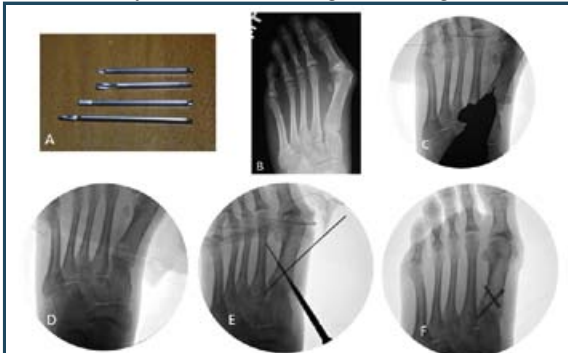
A: Isham burrs. B: X-ray showing hallux valgus deformity. C, D: Percutaneous lateral closing wedge osteotomy using an Isham burr under fluoroscopy to correct the varus deformity of the first metatarsal. E and F: insertion of two cannulated screws over the guide wires with the metatarsal in normal alignment.
